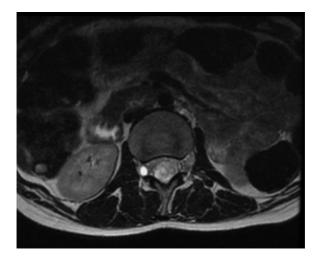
Axial MRI in T2-weighted image show arachnoidien cyst.
